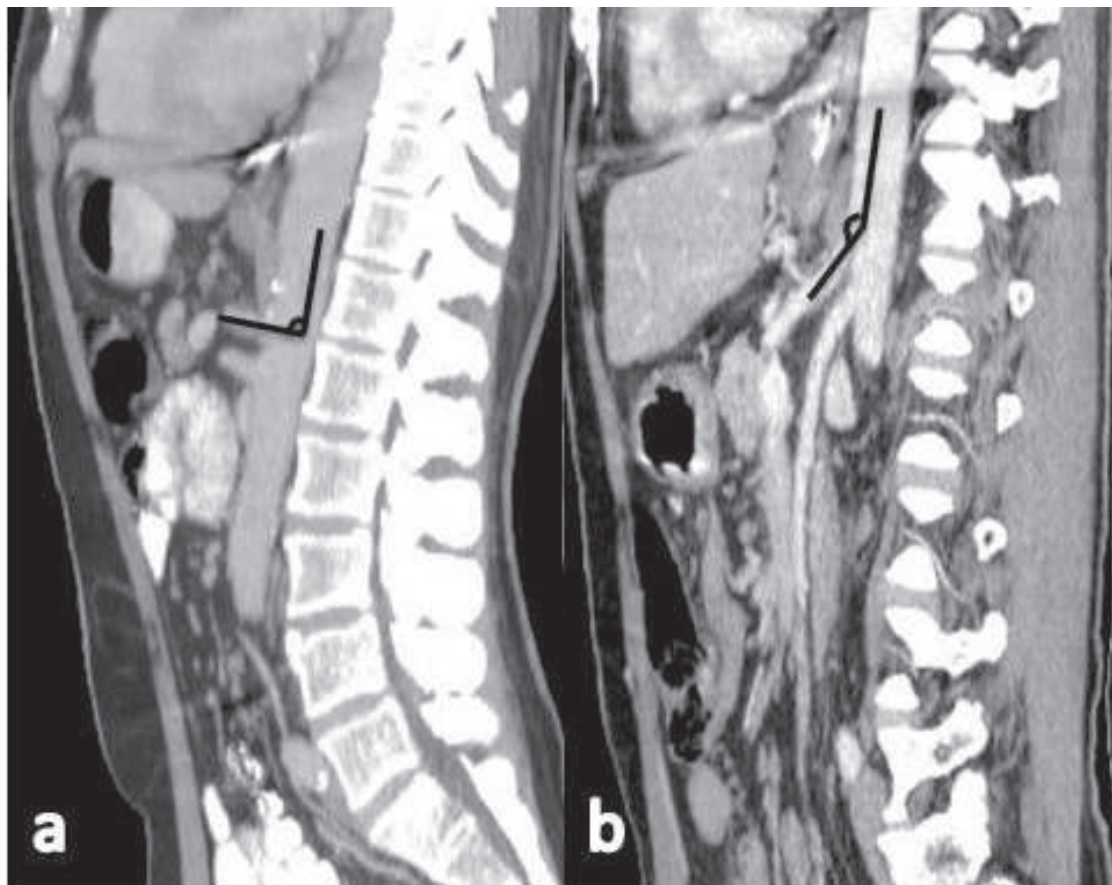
Sagittal contrast-enhanced abdominal CT image. Angle between the celiac trunk and abdominal aorta ranges between a. 90° and b. 150° .
